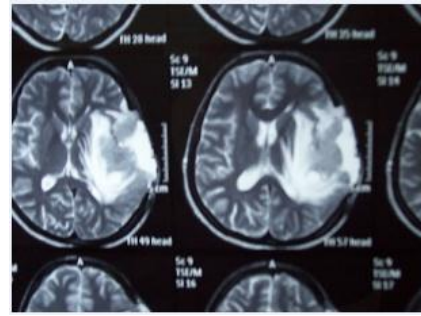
MRI brain revealed a large 7.0x7.0x6.6 cm non enhancing mass with evidence of solid and cystic component in the left temporal lobe, peri-insular and parietal region.
